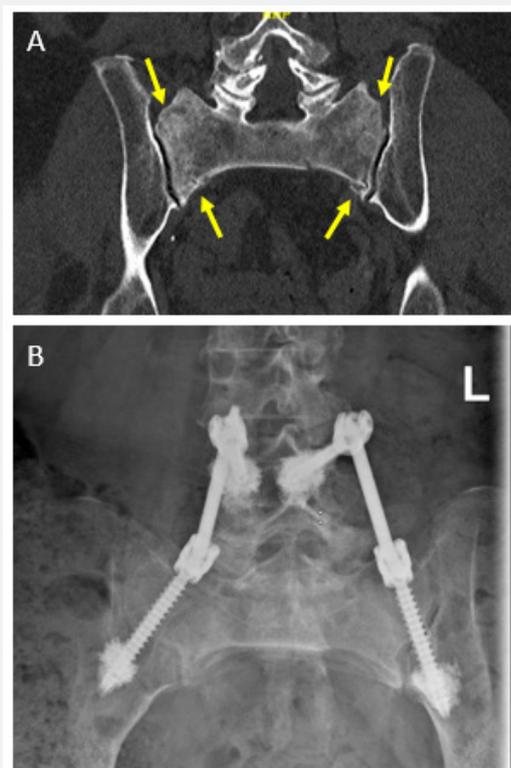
Type IVc fracture in a 72-year-old female. (A) Preoperative CT scan, (B) postoperative X-ray after bilateral cemented lumbopelvic stabilization.
